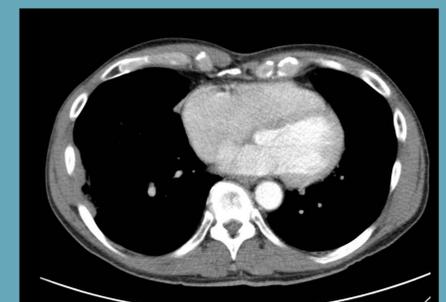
Follow up CT 6 weeks post treatment with >75% tumor reduction
